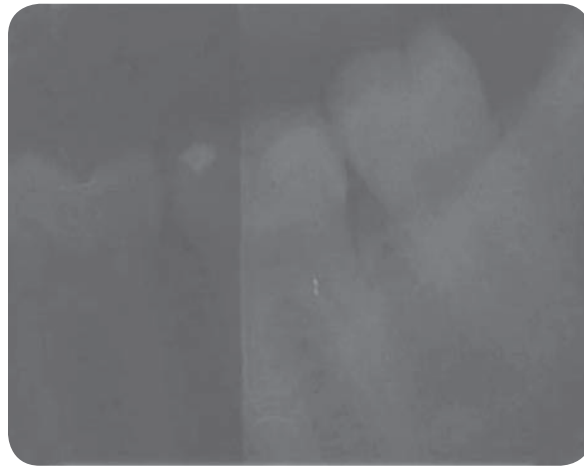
Right half of the radiograph is scrapped and lightened.
